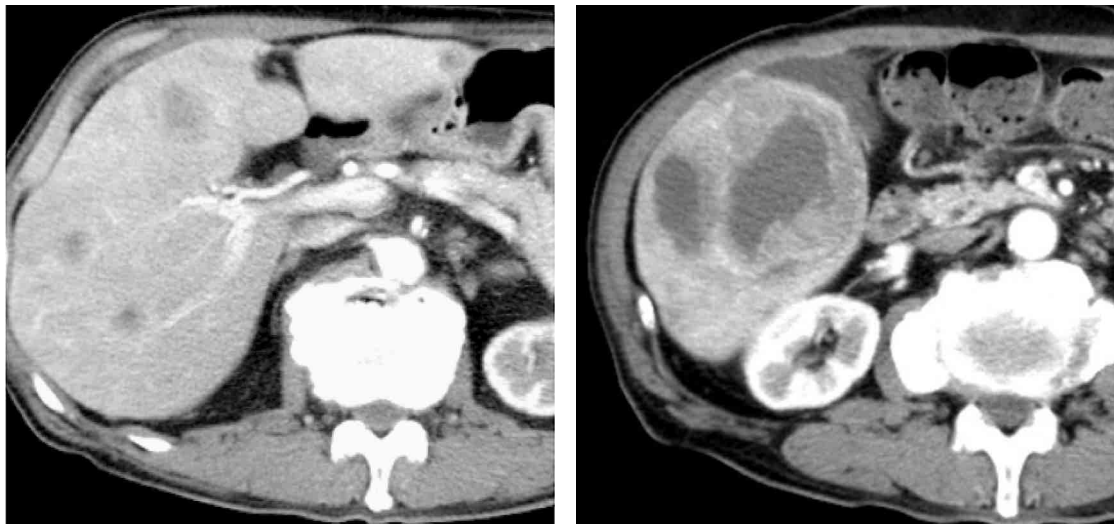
CT scan performed 1 month after operation found an increasing metastases focus in the liver.
